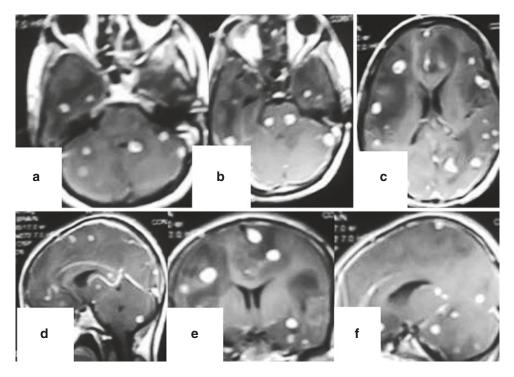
Contrast MRI of the brain, (a–c) axial images; (d) sagittal and (e, f) coronal images showing "panencephalic miliary tuberculomatosis"
